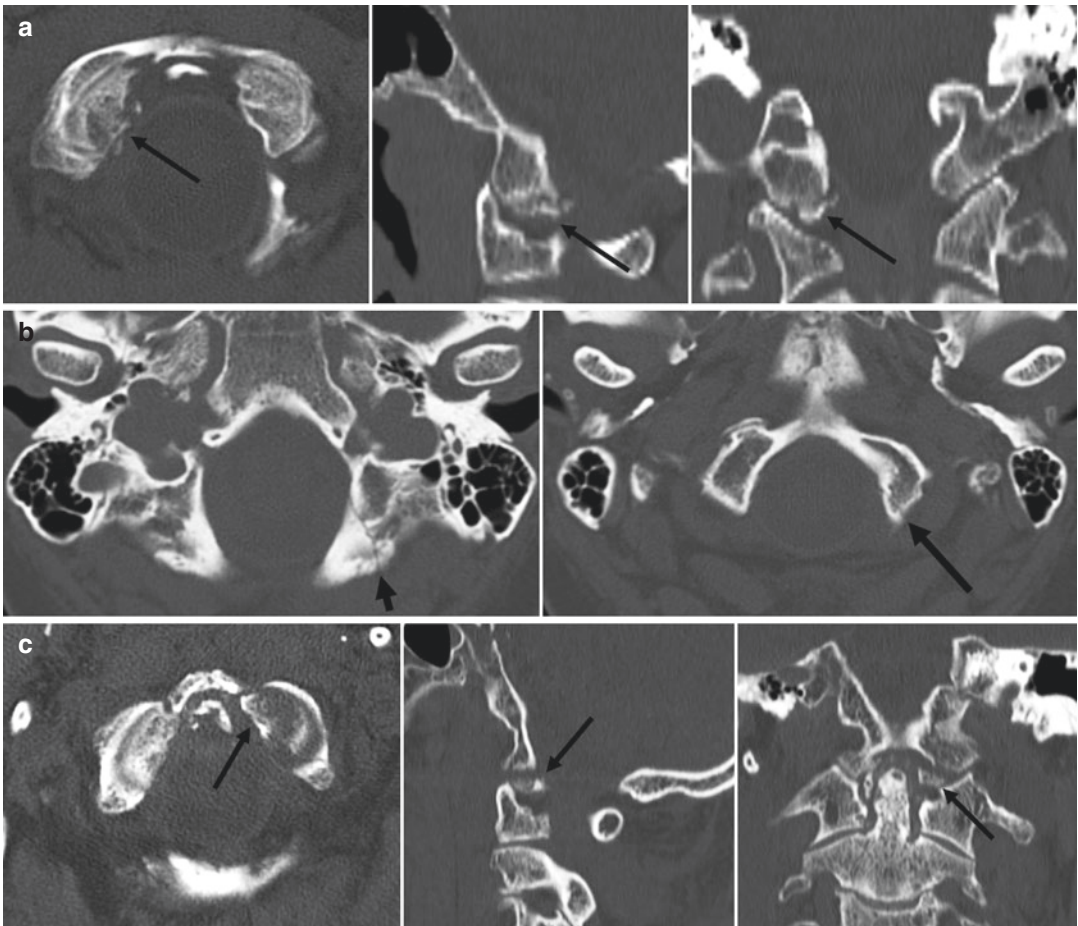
Occipital condyle fractures types I (a), II (b), and III (c): source axial and 2D-reformatted sagittal and coronal (a, c) and nonconsecutive source axial (b) CT images. *Black arrows* indicate the fracture lines
